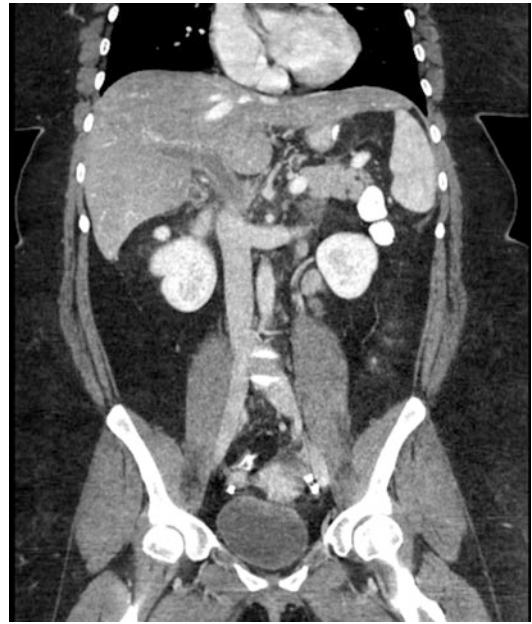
CT scan of the abdomen with IV contrast demonstrating massive portal vein thrombosis. The patient presented with severe epigastric and back pain
